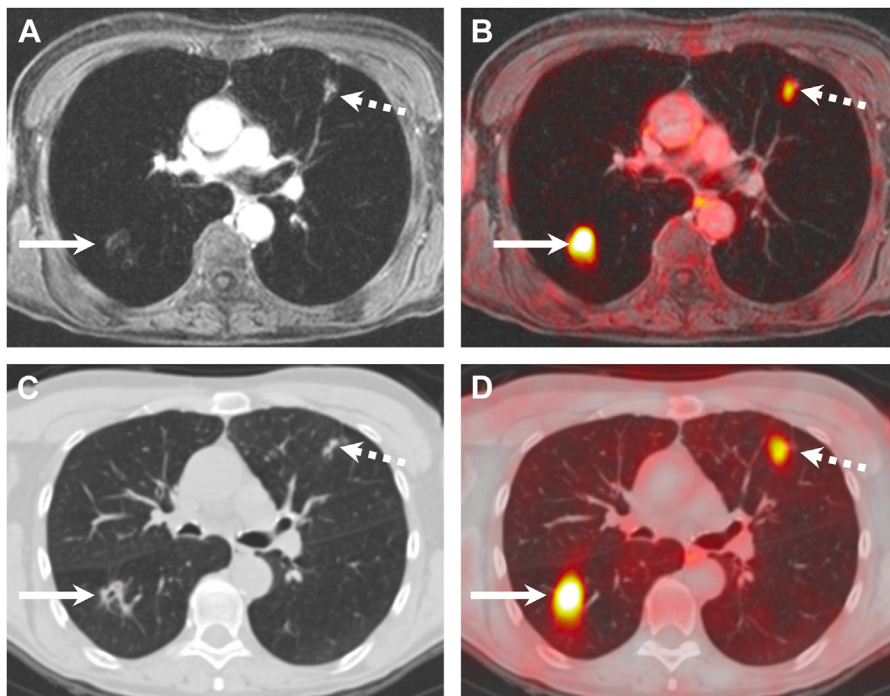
Lung metastases correctly diagnosed on PET/MR imaging (A, B) and PET/CT (C, D) in a 60-year old woman with nodal recurrence after radiochemotherapy for oropharyngeal HPV-negative SCC. The right upper lobe metastasis (arrows) shows a combination of high focal FDG uptake (SUVmax on PET/MR imaging = 7.7 and SUVmax on PET/CT = 9.3) and an excavated aspect on the contrast-enhanced fat-saturated MR image and on the corresponding CT image. The left upper lobe metastasis (dashed arrows) displays minor focal FDG uptake (SUVmax on PET/MR imaging = 1.7 and SUVmax on PET/CT = 2.1) and clustered nodules on the corresponding morphologic MR imaging/CT images. Both lesions were rated with a score of 5 (highly suspicious) on PET/MR imaging and PET/CT. (Reproduced from Katirtzidou et al.²⁴)
